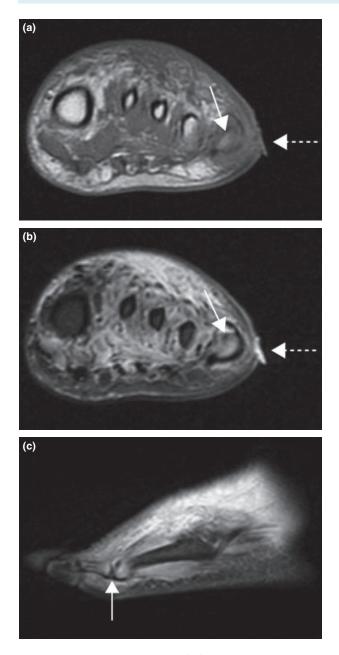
Magnetic resonance images of a foot with a neuropathic lesion at the lateral aspect of the fifth metatarsal head area: (a) coronal T1 weighted image demonstrating the ulcer (dashed arrow) and low signal intensity in the marrow of the fifth metatarsal (solid arrow) consistent with bone marrow oedema and osteomyelitis; (b) coronal T2 fat saturated image demonstrating the ulcer (dashed arrow) and hyperintensity in the underlying soft tissue extending down to the fifth metatarsal which is also returning hyperintense signal (solid arrow) consistent with bone marrow oedema and osteomyelitis; (c) sagittal T2 fat saturated image showing hyperintensity in the fifth metatarsal head and fifth proximal phalanx (solid arrow).
